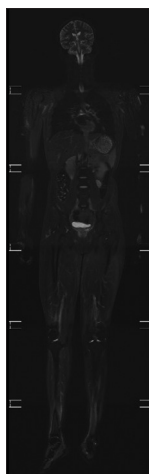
Whole body coronal STIR MRI images showing normal muscle intensities
